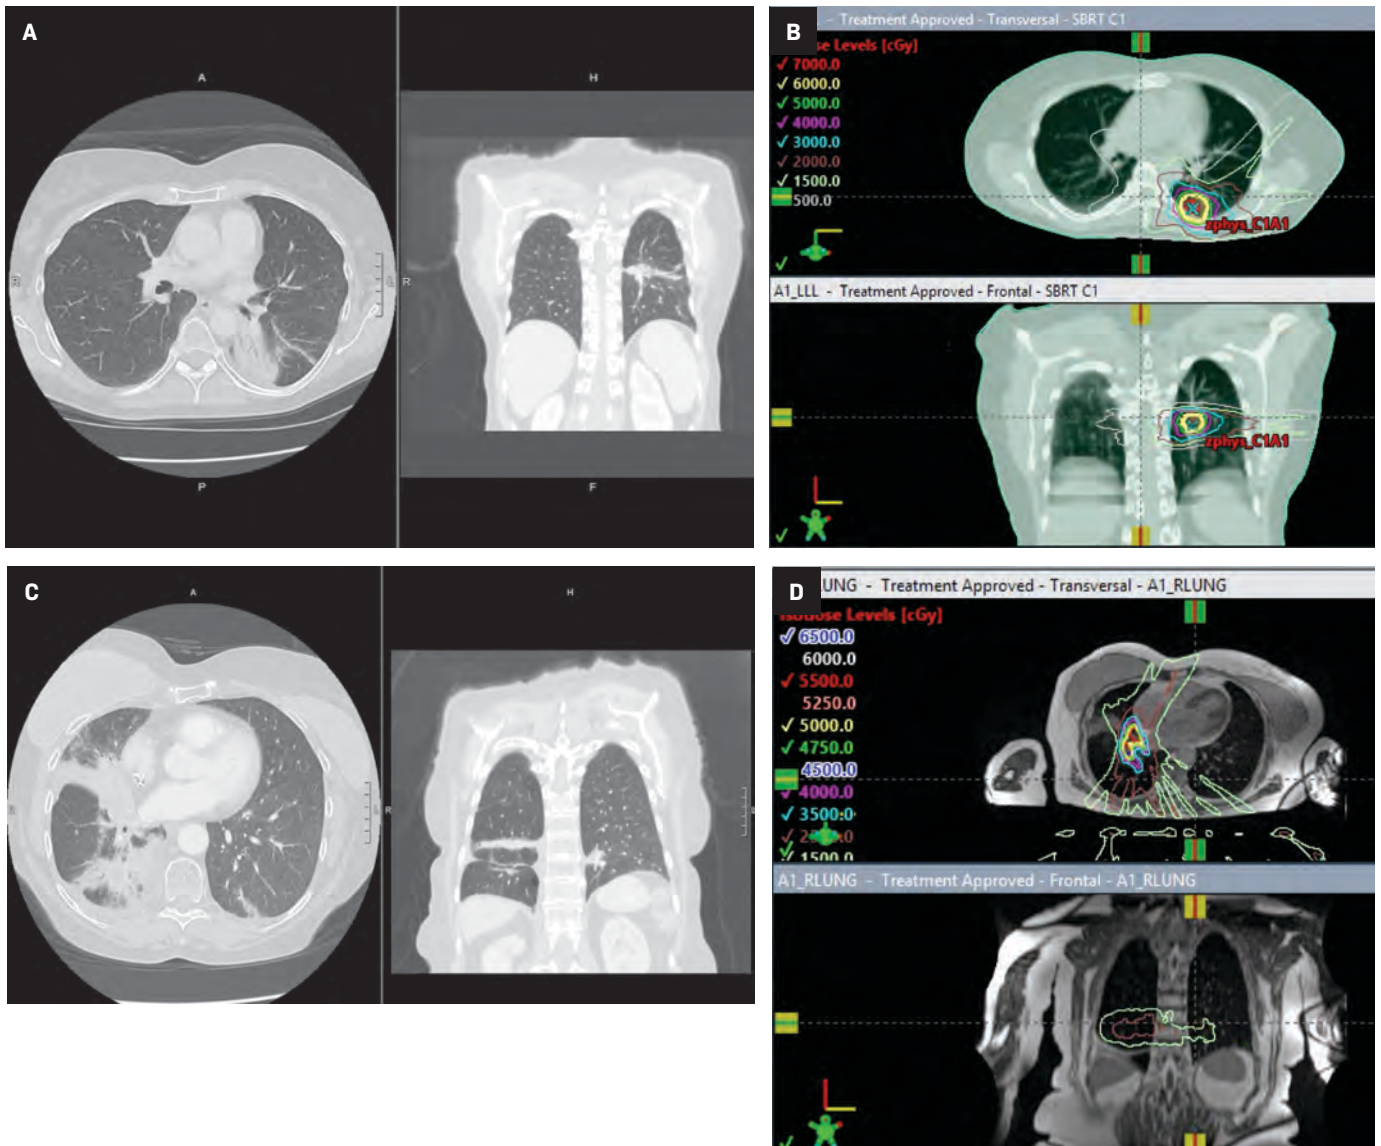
Radiation pneumonitis (RP) following treatment with volumetric-modulated arc therapy (VMAT) vs MR-guided intensity-modulated radiation therapy (IMRT). Axial (left) and coronal (RT) chest computed tomography (CT) for a patient with Grade 1 RP treated with VMAT (A). Corresponding VMAT plan, with 15-20 Gy isodose lines conforming to the tumor shape and correlating with consolidation seen at CT (B). Axial (left) and coronal (right) CT chest for a patient with grade 1 RP treated with MR-guided IMRT (C). Corresponding IMRT plan, showing 15-20 Gy isodose lines correlating with consolidation in contralateral and ipsilateral lung (D).
